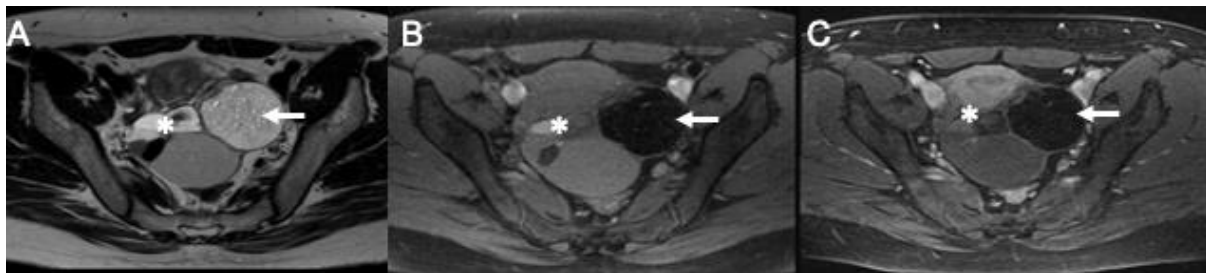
MRI of collision tumor. Collision tumor in the left ovary of a struma ovarii (asterisk) and MCT (arrow). A) Axial T2-weighted image. B) Axial T1-weighted image with fat suppression. C) Axial T1 FS. G. Multi-locular cyst with multiple loci with different signal intensity (asterisk), corresponding to struma ovarii.
